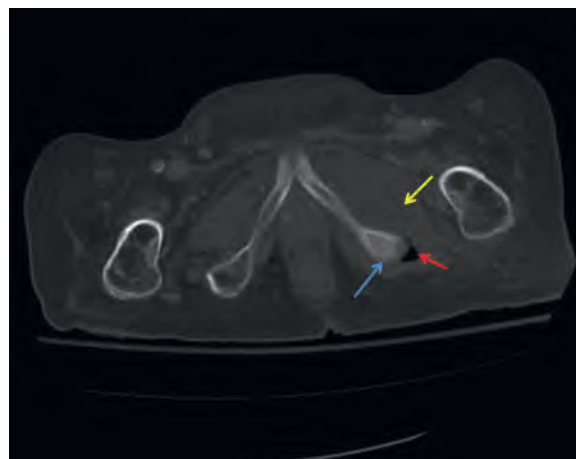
Contrast-enhanced computed tomography scan of the pelvis in a spinal cord-injured patient with an unhealed ischial pressure sore. Note the presence of chronic osteomyelitis (blue arrow), inflamed muscle (yellow arrow), and soft tissue defect (red arrow).
